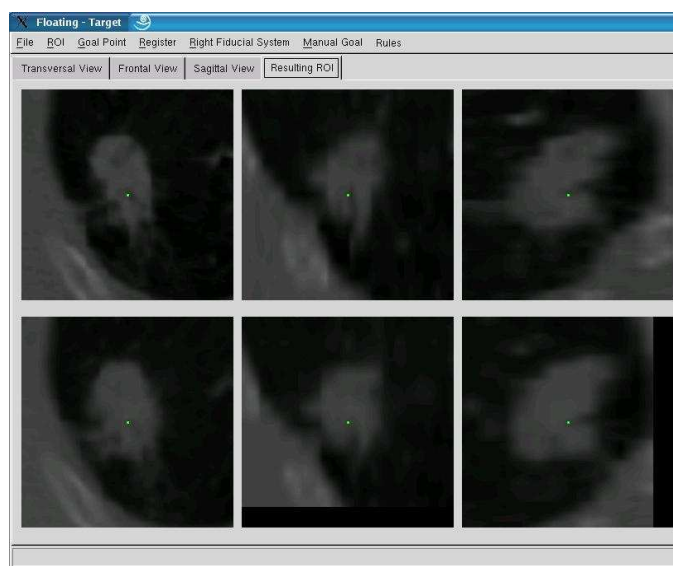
Result of the 3D-3D local rigid registration. The first row corresponds to the planning CT, from left to right, transversal, sagittal and frontal view and the second row corresponds to the region found in the therapy CT.
